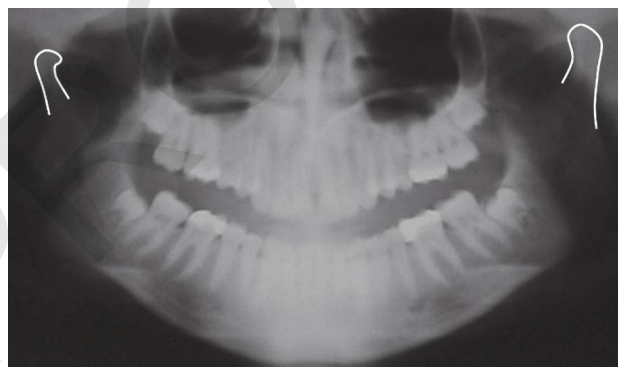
Panoramic radiographic examination.
